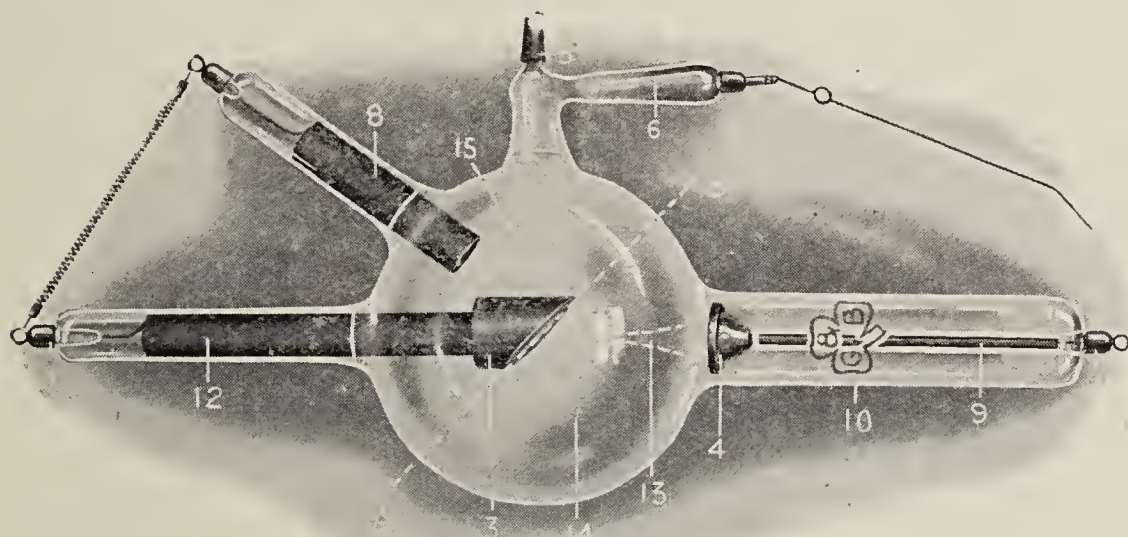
X-RAY GAS TUBE.
